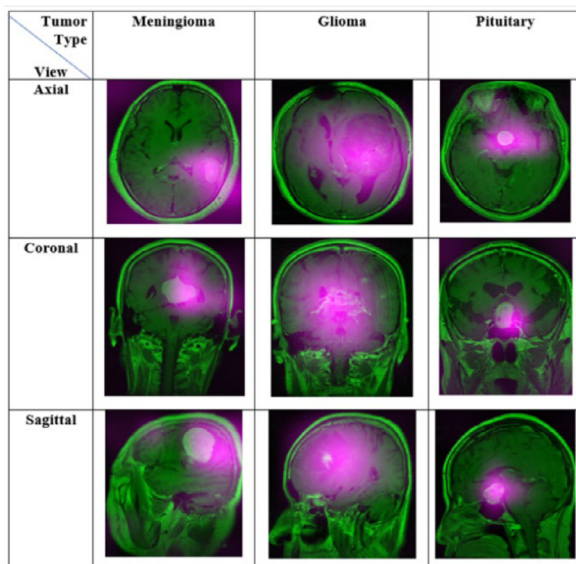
Different tumor localization using DarkNet-53 pre-trained model from multi-orientation MR images.. (For interpretation of the references to color in this figure legend, the reader is referred to the web version of this article.)
